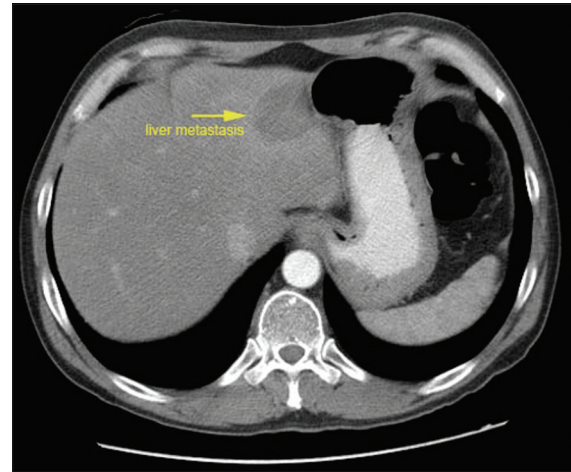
Preoperative CT of the liver
